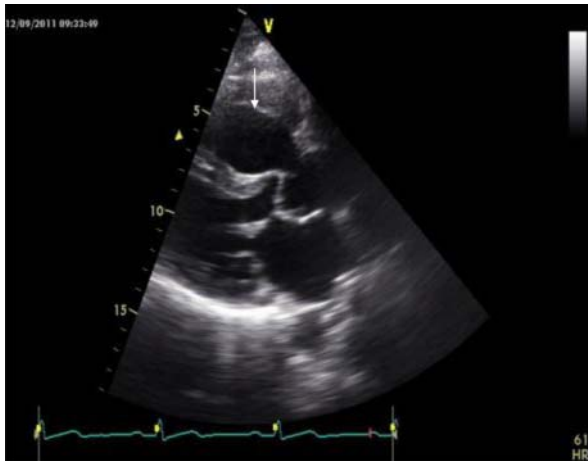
Transthoracic echocardiography. Parasternal long axis view shows an aneurysm of the right coronary sinus (arrow).
